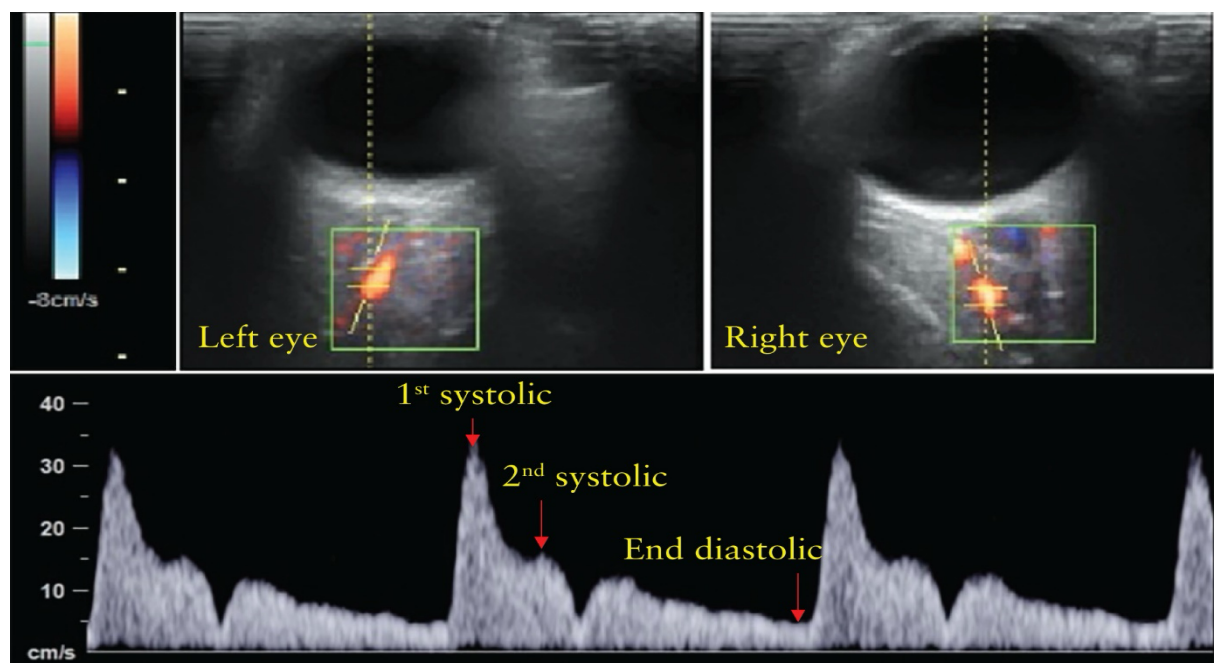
Ultrasound images of left and right orbits with color flow demonstration of left and right ophthalmic arteries. At the bottom is flow velocity waveform from ophthalmic artery obtained by pulsed-wave Doppler, showing first and second peaks of systolic velocity and end-diastolic velocity
